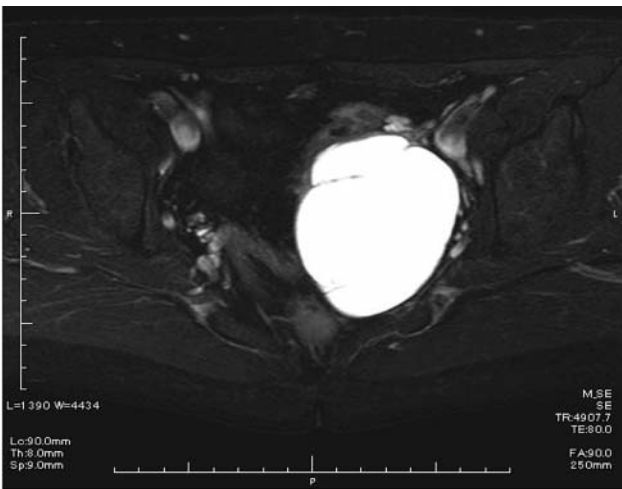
Case 1, MRI, T2-weighted, fat suppressed images, showed a multicystic mass of hyperintensity measuring 63 × 90 × 68 mm.
